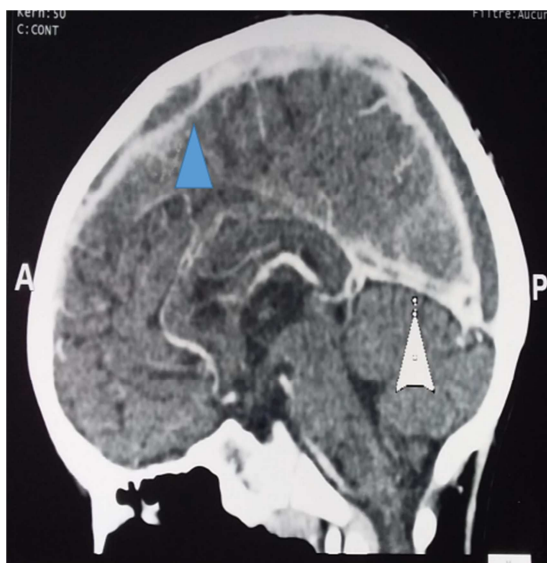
Angio MRI. Thrombosis of the right sinus (white arrow) and the superior sagittal sinus (blue arrow): absence of opacification of the sinus.
